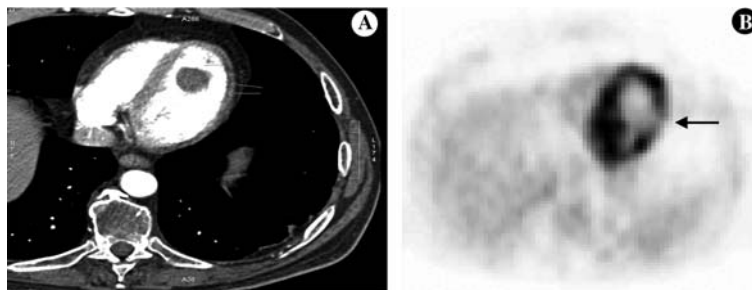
(A) Contrast enhanced axial CT image shows myocardial thinning and subendocardial hypoenhancement along inferolateral region (small arrows) with intraventricular thrombus. (B) Axial F-18 FDG PET images show a corresponding metabolic defect, viz. without significant FDG uptake along inferolateral area (single black arrow).
